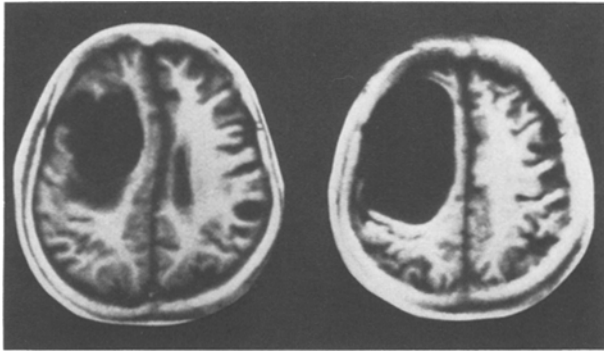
T₁ weighted MRI showing marked compression of the frontal lobe by the cyst
